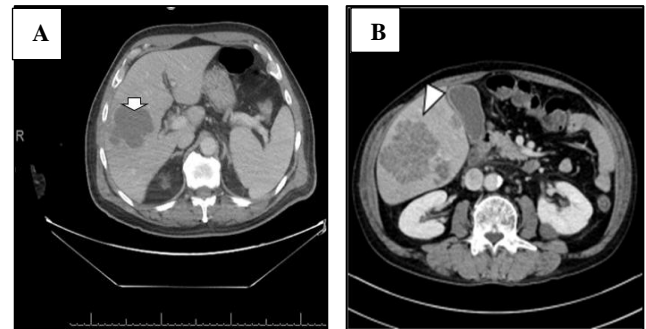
Contrast enhanced CT liver before PCD.
